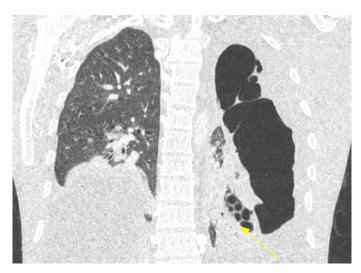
Coronal CT slice demonstrating multiple daughter cystic vesicles within the pleural fluid collection (yellow arrow)
